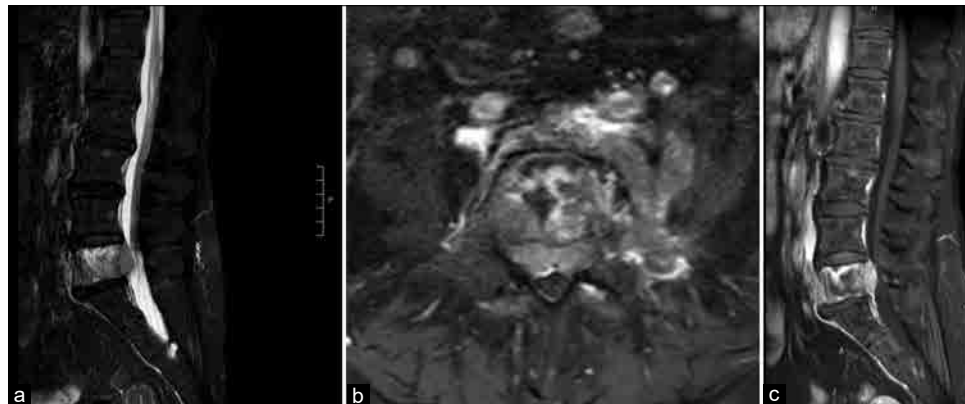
Preoperative thoracolumbar spine MRI showed a L5 osteolytic and epidural lesion hyperintense in sagittal STIR sequences (a) with a high and inhomogeneous post-contrast enhancement in T1-Gd axial and sagittal sequences (b and c).
